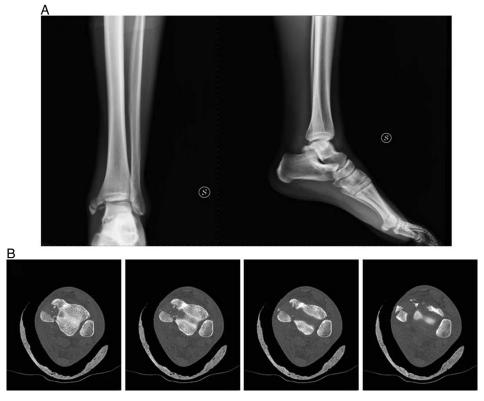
(A) Preoperative radiographs and (B) computed tomography scans showing an isolated multifragmented tibial malleolar fracture.
